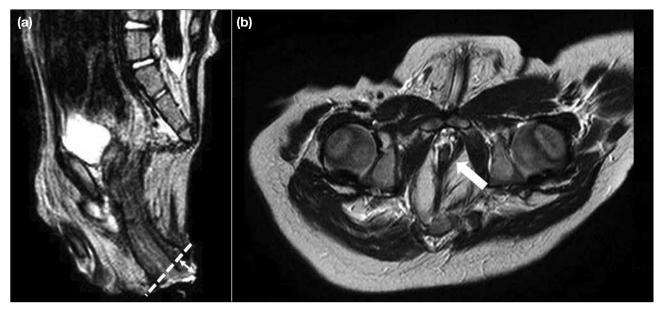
Anorectal prolapse. This male patient presented with a rectovesical fistula with high-type anorectal malformation at age 2 years. Laparoscopically assisted anorectoplasty had been performed as the second surgical repair at age 10 months. After the second surgical repair, anorectal prolapse occurred. Therefore, surgical repair (Gant-Miwa method) was performed at age 2 years. (a) T2-weighted sagittal magnetic resonance imaging showing rectal and anal depression from the pelvic floor to the distal side. Rectal prolapse is located at 7 mm (double headed arrow) from the skin around the anus [dashed line]. (b) Axial T2-weighted magnetic resonance imaging in a male infant aged 6 months with rectovesical fistula. It detects asymmetrical puborectalis muscle only on the left side (arrow), which cannot be clearly visualised.
